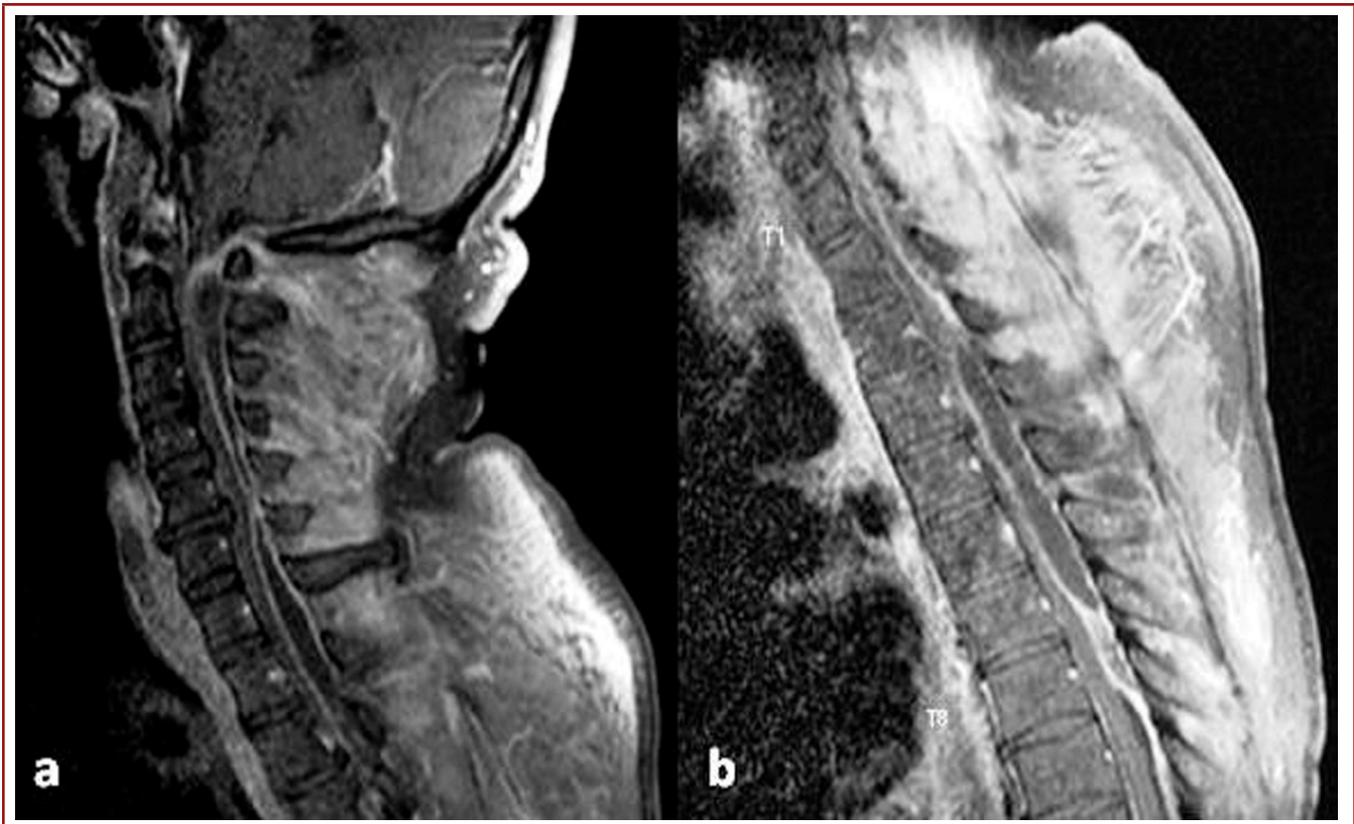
a-b) This postcontrast sagittal T1-weighted cervico-thoracic MRIs demonstrated a space occupying lesion with a ring-enhancement and spinal cord compression extending from C1 to T8 levels. The lesion was compatible with an abscess.
